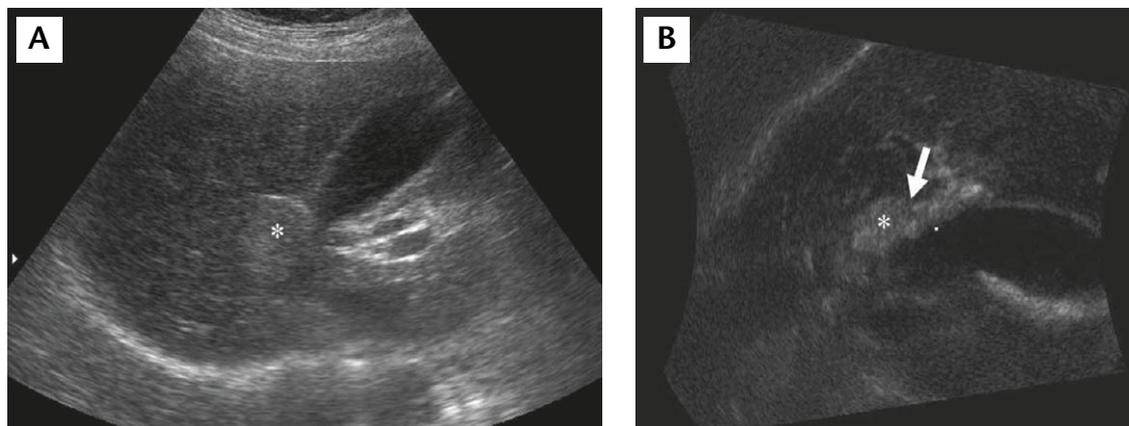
Coronal multiplanar reformatted image providing additional information in terms of the location of the lesion. (A) On transverse ultrasound image, an echogenic mass (*) is seen between the right lobe of the liver and the gallbladder. However, the origin of the mass cannot be determined only by this image. (B) Coronal reformatted three-dimensional image shows the presence of beak sign (arrow) between the mass (*) and hepatic parenchyma, suggesting an intrahepatic lesion. From this information, we can confidently interpret that this mass has arisen from the liver. The mass was confirmed as a hepatic hemangioma on subsequent magnetic resonance imaging.
